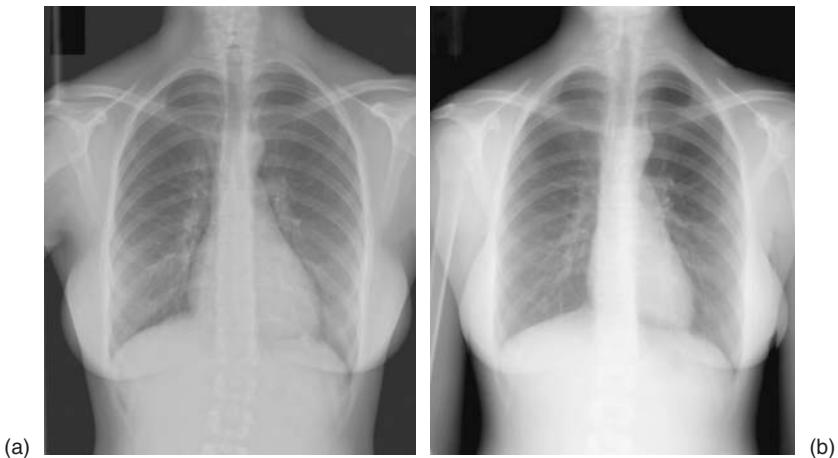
Chest radiograph done before (a) and after (b) surgical repair of VSD defect, demonstrating a reduction in size of the cardiac silhouette.
